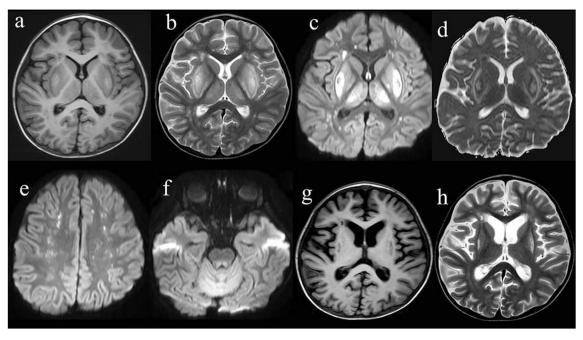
MRI on day 16 (a-f), and day 54 (g and h). T1- weighted image (a) showed T1 high signal lesions in the bilateral putamen, and low signal lesions in the internal and external capsules. T2-weighted image (b) showed T2 high signal lesions in the bilateral putamen, internal and external capsules, and dorsolateral thalamus. DWI showed high signal lesions in the bilateral putamen, thalamus and dorsal pons, and multiple spotty lesions in the cerebral white matter (c, e and f). ADC showed increased diffusion in the bilateral putamen, and internal and external capsules (d). On day 54, T1 (g) and T2 (h)-weighted images showed low and high signal lesions in the bilateral putamen, respectively.
